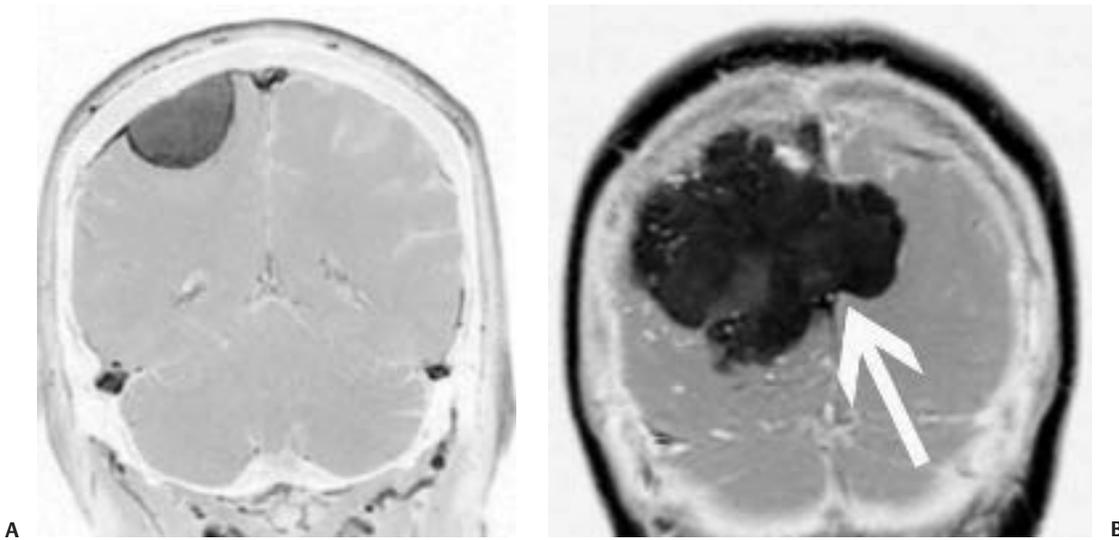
Typical appearance of meningioma on magnetic resonance imaging (MRI). (A) Coronal postcontrast T1-weighted MRI demonstrate avid homogeneous enhancement and a dural tail of a convexity meningioma arising from the dura overlying the right parietal lobe. Note that the sagittal sinus is separated from the meningioma by normal brain. (B) A large falcine meningioma does not respect the dural boundary and extends on both sides of the falx.
